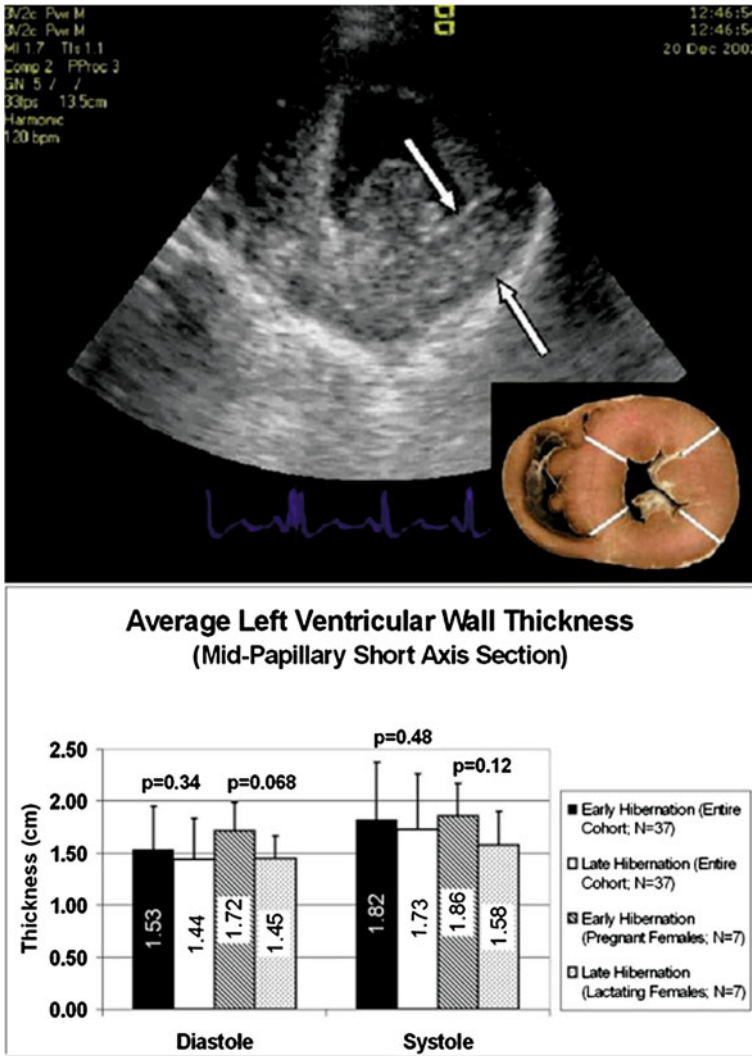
Top panel* -Cross-sectional echocardiographic image showing left ventricular wall thickness of black bears. *Bottom panel* -Plot of wall thickness in early and late winter (Laske et al. 2010)
